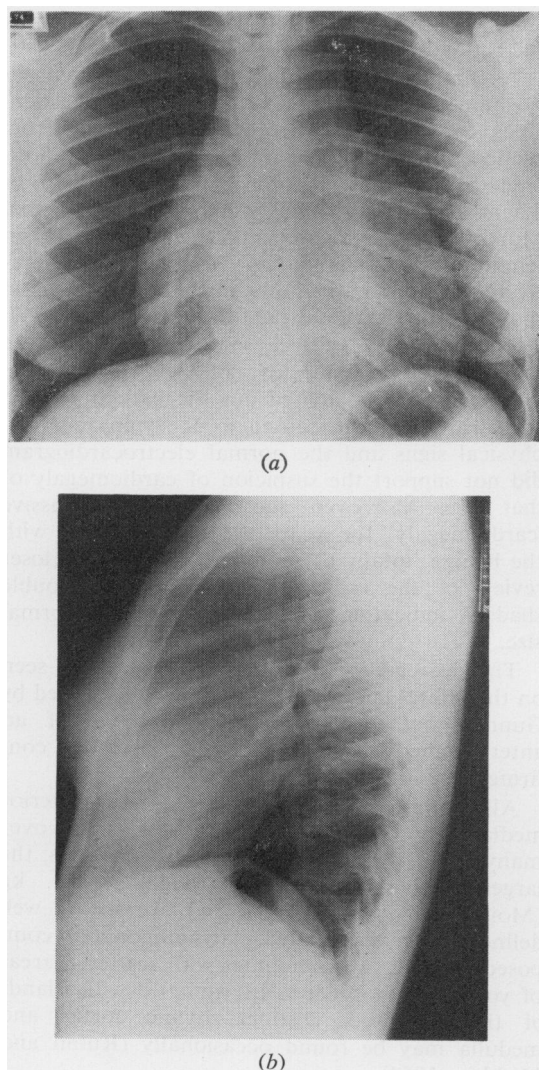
Preoperative chest radiograph in P-A (a) and in lateral (b) positions.
